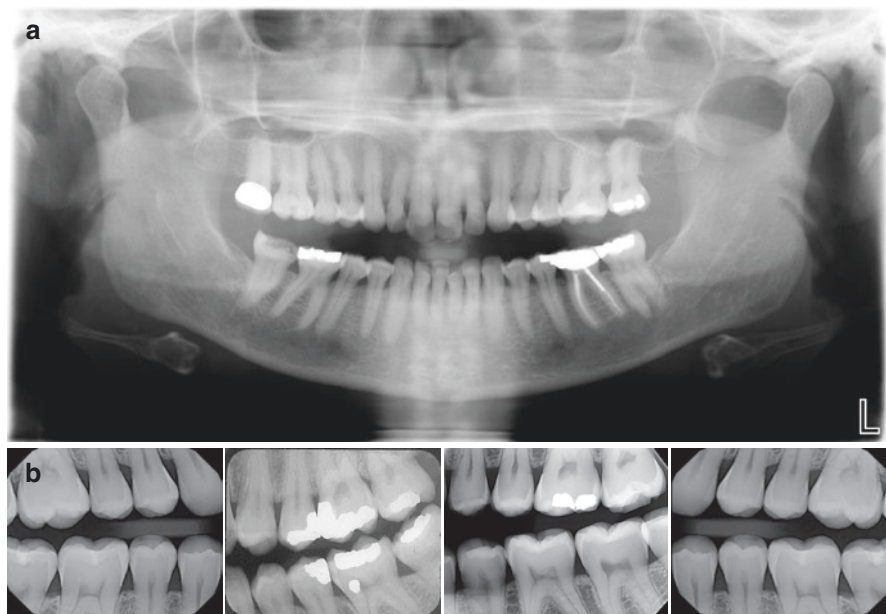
Routine radiographic evaluation of teeth. (a) Panoramic radiograph. (b) Bitewing radiographs
